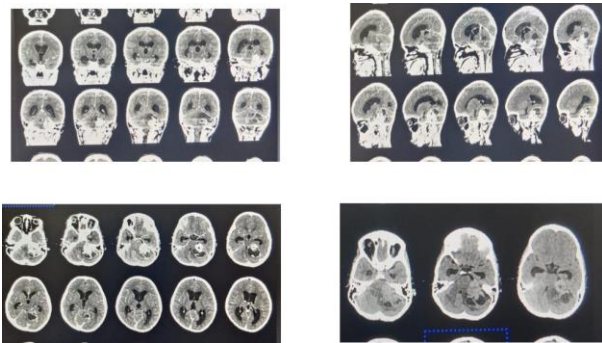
Preop CT scan of patient showing the left CP angle lesion
